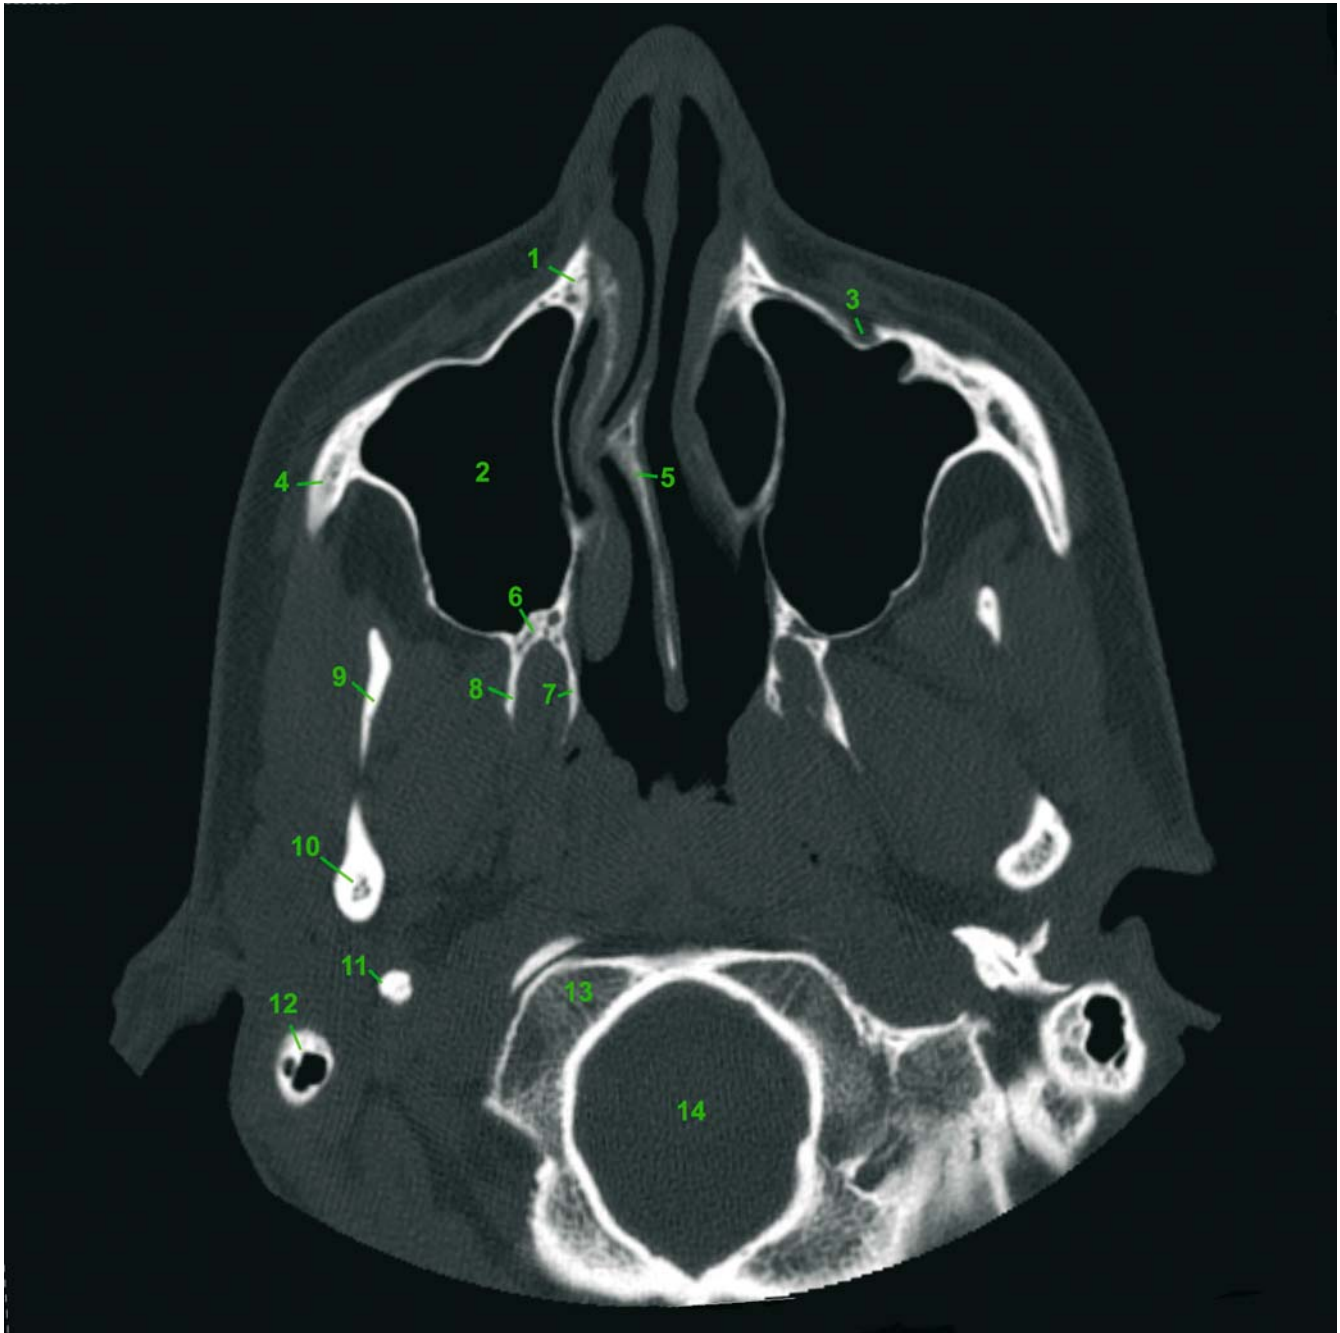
Axial CT slice 6 (patient K.C.). 1 Maxillary bone; 2 Maxillary sinus; 3 Infraorbital canal; 4 Zygomatic bone; 5 Nasal septum; 6 Palatine bone; 7 Medial lamina of pterygoid process; 8 Lateral lamina of pterygoid process; 9 Coronoid process of mandible; 10 Condylar process of mandible; 11 Styloid process; 12 Mastoid process; 13 Occipital condyle; 14 Great foramen (foramen magnum)
